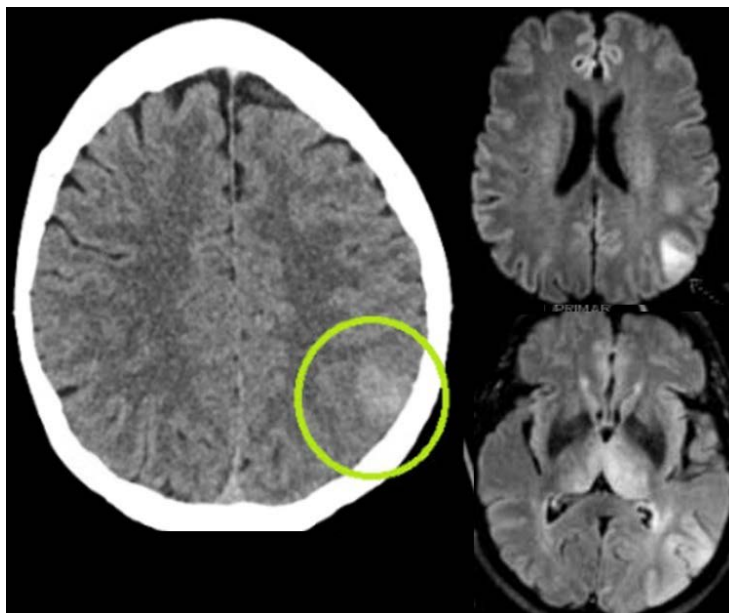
High-grade glioma. A 60+ y/o patient presented with an acute onset of speech disturbance while at work. The exam showed paraphasic errors, disorientation, dyscalculia, and body agnosia. In the left image, CT demonstrated hyperdensity in the superior left frontal-temporal region without enhancement, resembling subarachnoid hemorrhage (green circle). Diffusion-weighted images (inserts to the right) showed hyperintensity in the left temporoparietal lobes and bilateral thalami. Pathology yielded IDH wild-type glioblastoma.
